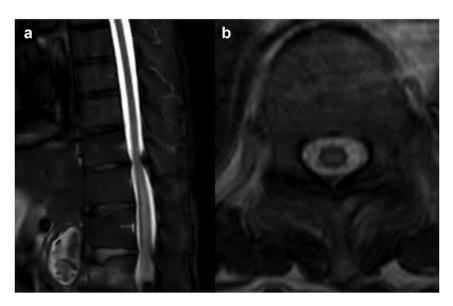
Sagittal (a) and axial (b) images of T2-weighted magnetic resonance imaging performed 2 days after onset showing an intramedullary high intensity area below Th11.
